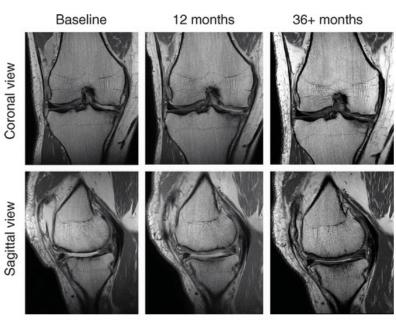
Sequential coronal and sagittal MRI proton density images of participants knee at baseline, 12 and 36+ months. (Freiteg, 2020)
